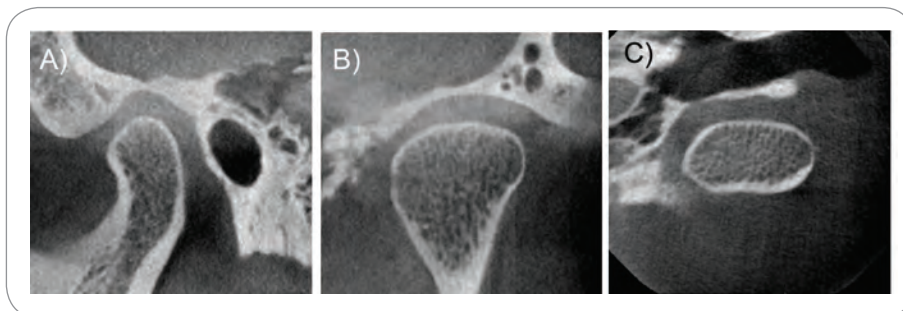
Normal TMJ in the closed position seen on corrected lateral (A), coronal (B), and axial (C) CBCT sections.
